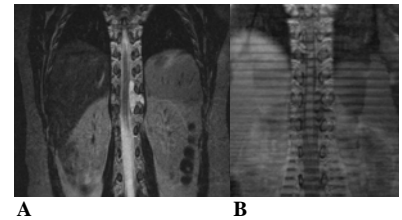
Images of a 28-year-old female patient who had spinal arachnoid cyst. A, coronal T2-weighted magnetic resonance image showed left lateral arachnoid cyst in T11-T12 level. On the SPAMM MRI (B), downward shift of tagging band in the arachnoid cyst showed parabolic shape with velocity similar to CSF flow around normal spinal cord.
